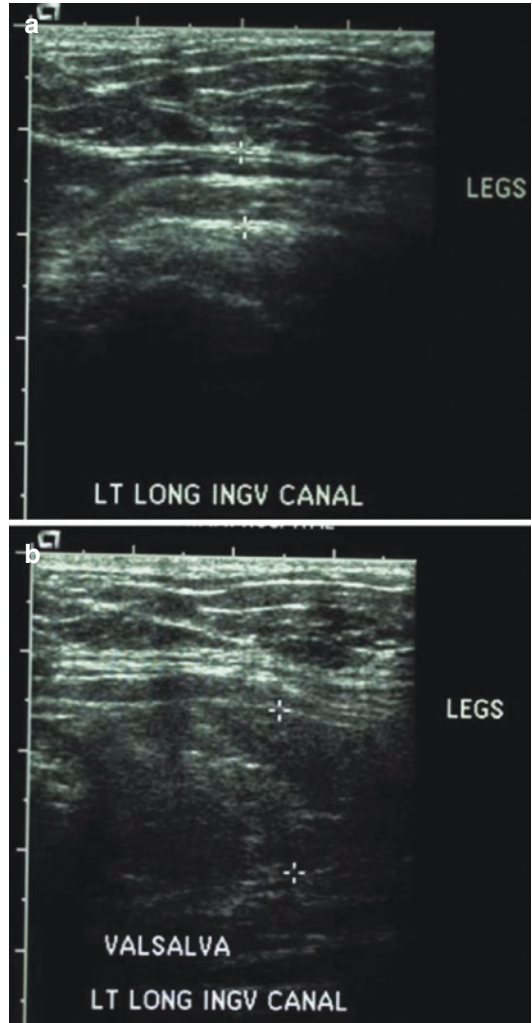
(a) Inguinal ultrasound at rest and (b) with Valsalva. Note separation of external oblique and floor with Valsalva. With permission from Young J, Gilbert AI, Graham MF. The use of ultrasound in the diagnosis of abdominal wall hernias. *Hernia: the journal of hernias and abdominal wall surgery.* 2007;11(4):347–351
